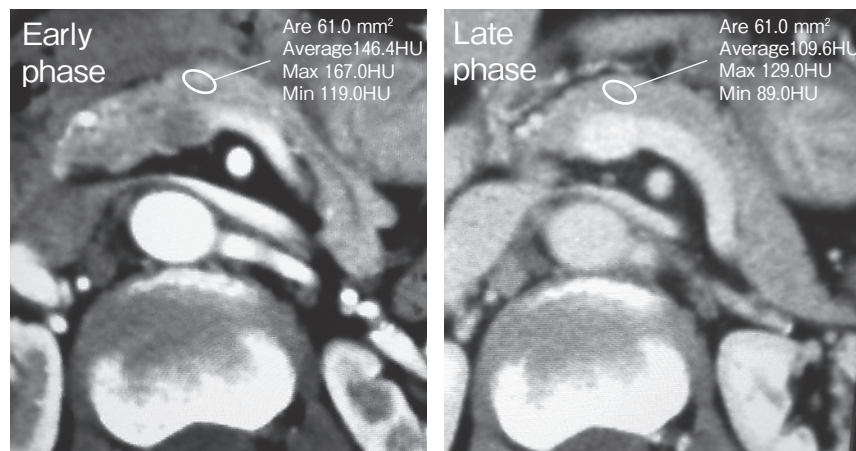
Measurement of the late phase to early phase ratio. Computed tomography (CT) attenuation values were measured on enhanced images obtained in the pancreatic (early) and hepatic (late) phases after contrast administration. CT attenuation values of the pancreatic parenchyma were quantified using Hounsfield unit thresholds by placing a region of interest in the pancreas body. The enhancement ratio expressed as the late phase/early phase ratio (L/E ratio) was calculated as (hepatic phase – unenhanced phase)/(pancreatic phase – unenhanced phase) to indicate delayed-phase enhancement.
